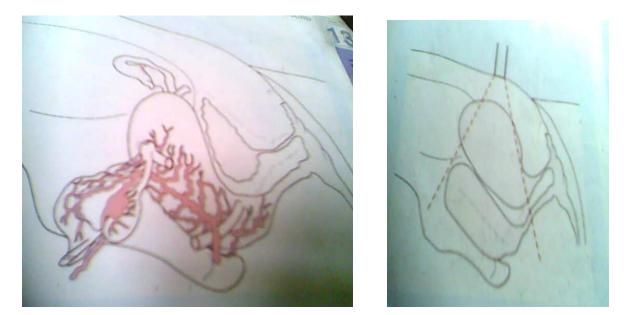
(A) Sagittal sections through the pelvis demonstrating the optimum geometry Achieved by transvaginal scan With an empty bladder (B) Sagittal planes through abdomen that with a full urinary bladder the geometry for Doppler assessment of flow is suboptimal.
